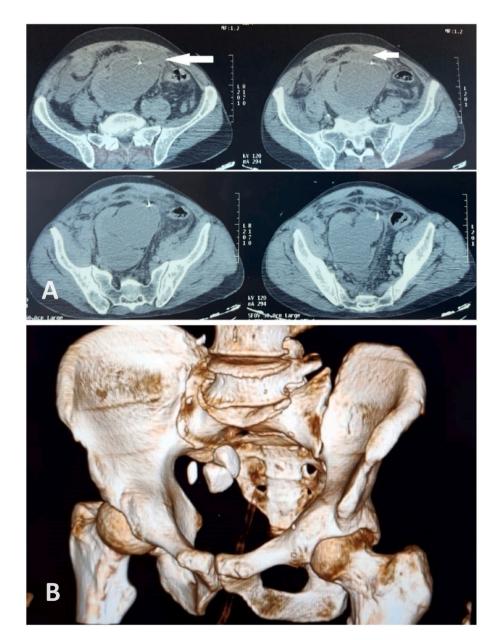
CT-scan showing kidney stones, pyelocaliceal dilation, and para-renal collections A: Cross section of a CT scan showing a huge pyelocaliceal dilatation in ectopic pelvic kidney complicated with two para-renal collections in the upper pelvis. B: 3D reconstruction of the CT-scan visualizing the responsible kidney stones (JJ removed).
